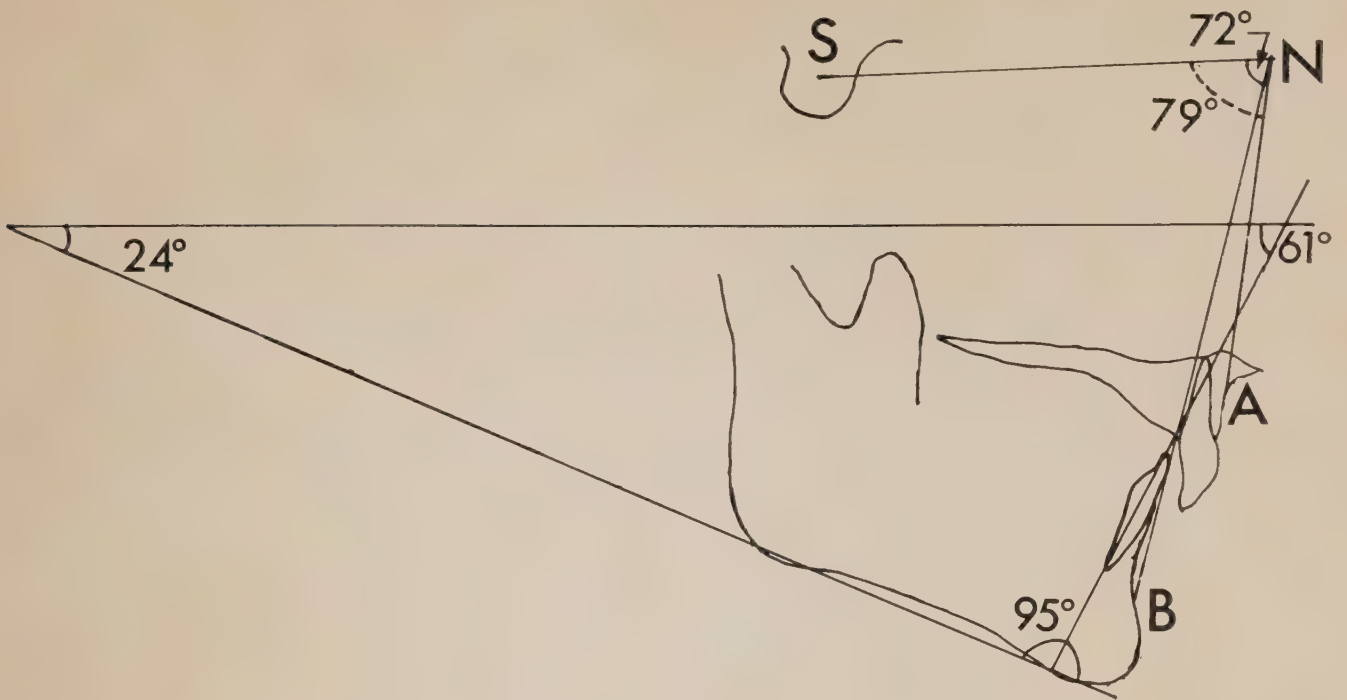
Tracing of a lateral skull radiograph of the patient, indicating angulations used in the cephalometric analysis. Landmarks are S, sella turcica; N, nasion; A, subspinale; B, supramentale.
